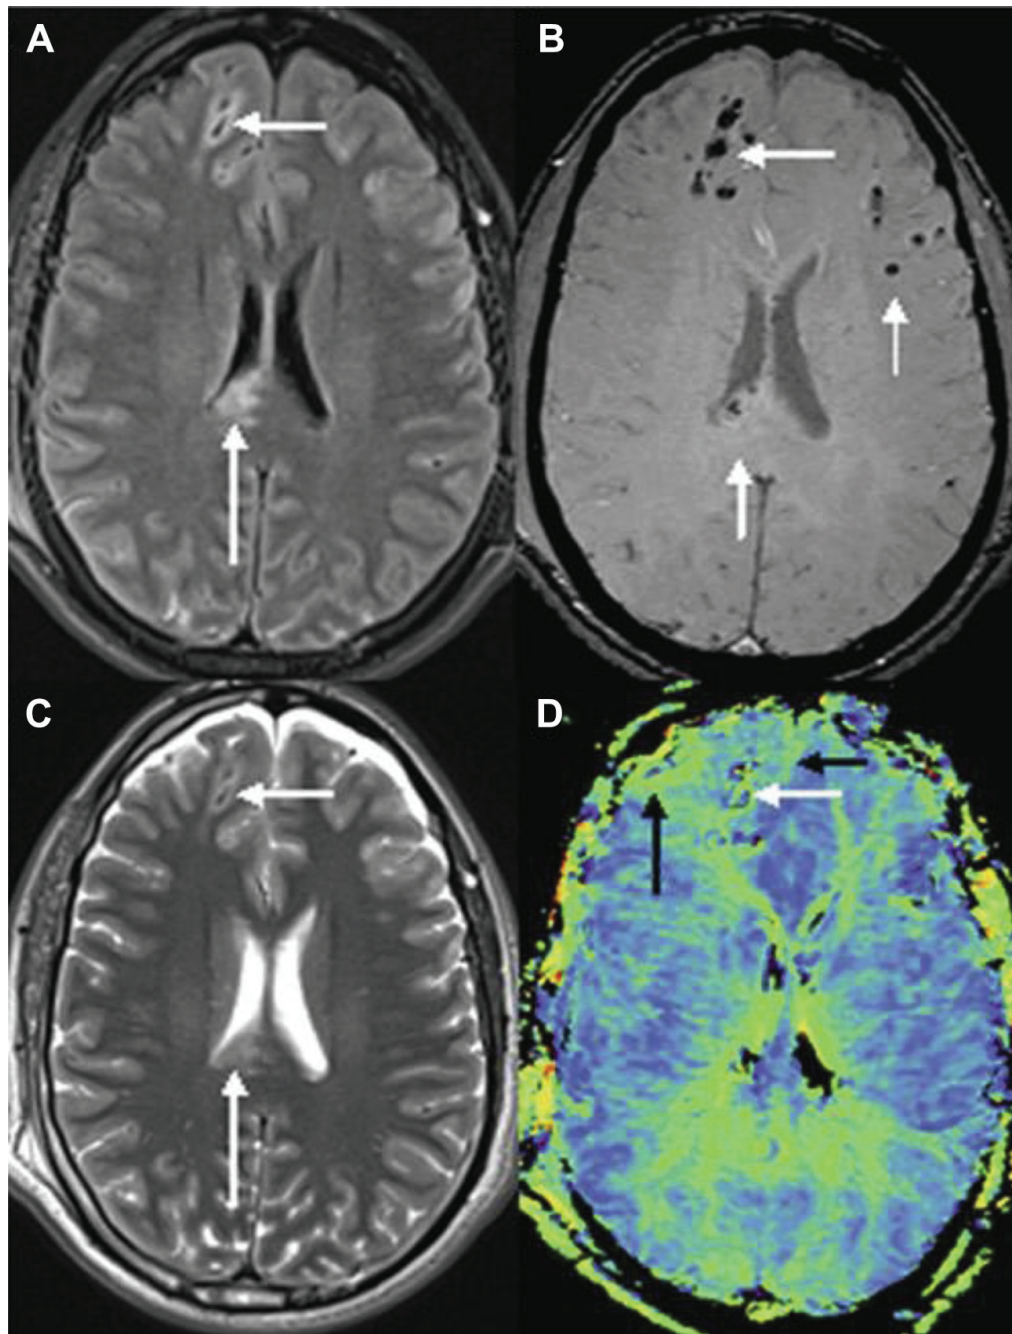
Frontal medullary vein damage and microbleeds in a patient with TBI. (A) FLAIR image and (C) T2-weighted scan showing 2 of the damaged frontal areas (*short arrow*) and enhanced signal in the splenium of corpus callosum (*long arrow*). (B) SWI showing multiple bleeds in the frontal, lateral, and the splenium of the corpus callosum (*short arrows*). (D) Mean transit time images from the PWI data showing possible delayed arrival times in frontal regions and medial gray matter regions (*black arrows*) representing reduced perfusion to these tissues. Note the dark regions correspond to the bleeds (eg, area denoted by *white arrow*), and because of the long echo times used for PWI, the signal there was too small to be used to determine PWI parameters correctly and hence are set to zero here. (From Haacke EM, Raza W, Wu B, et al. The presence of venous damage and microbleeds in traumatic brain injury and the potential future role of angiographic and perfusion magnetic resonance imaging. In: Kriepke CW, Rafols JA, editors. Cerebral blood flow, metabolism, and head trauma: the pathotrajectory of traumatic brain injury. New York: Springer; 2013. p. 75–94; with permission.)
